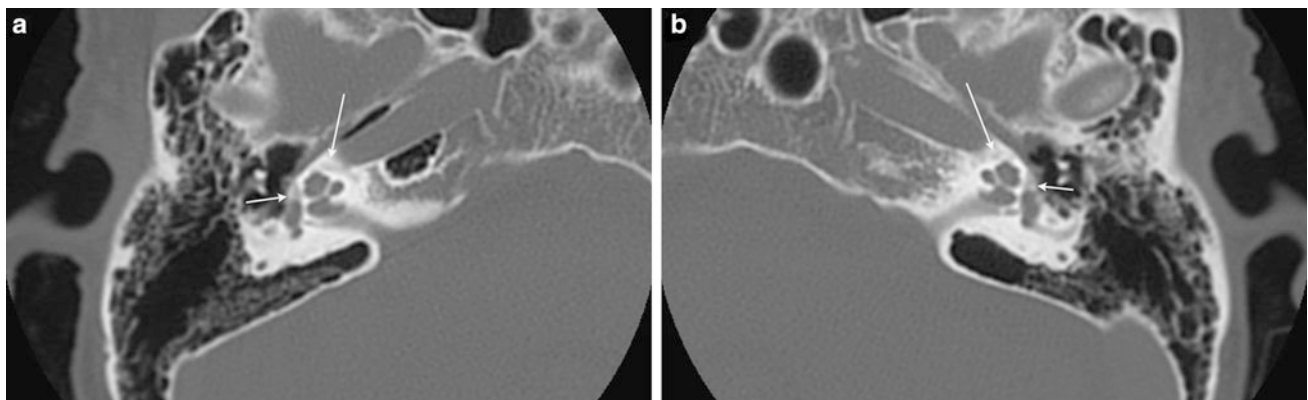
The axial CT images at footplate level are shown in both temporal bones from a patient with proved osteogenesis imperfecta. Note that the bone in the region of the fissula ante fenestram (*small arrow*) and in the pericochlear region (*large arrow*) has become
